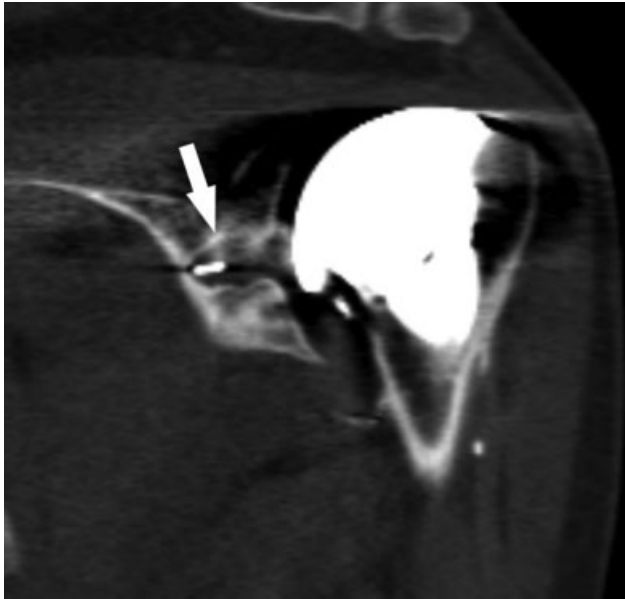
Coronal computed tomography image of a left shoulder showing partial osteointegration of the central peg. Note the presence of bone in some spaces between the fins of the central peg (arrow).
